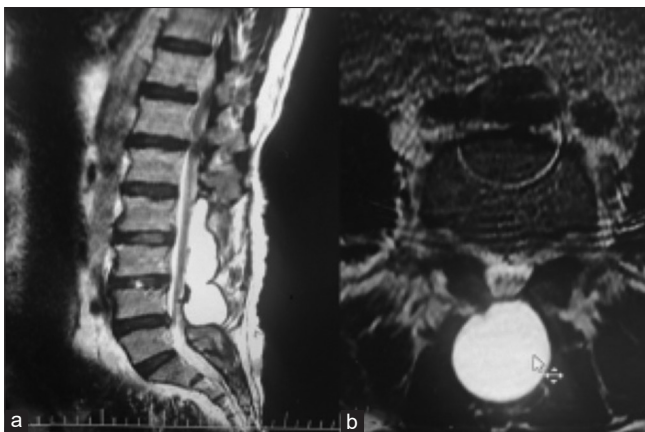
T2-weighted magnetic resonance imaging, (a and b) sagittal image showing a high-intensity cyst extending from L4 to S2, (c) axial view demonstrates that the cyst is multilobulated.
